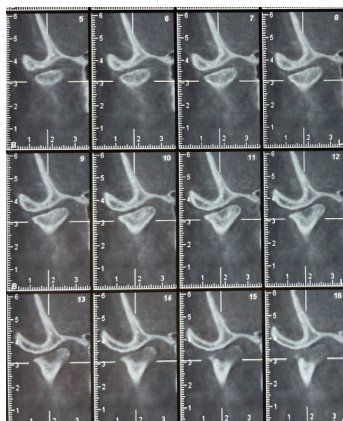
CBCT from right TMJ revealed flattening of the condylar head.
